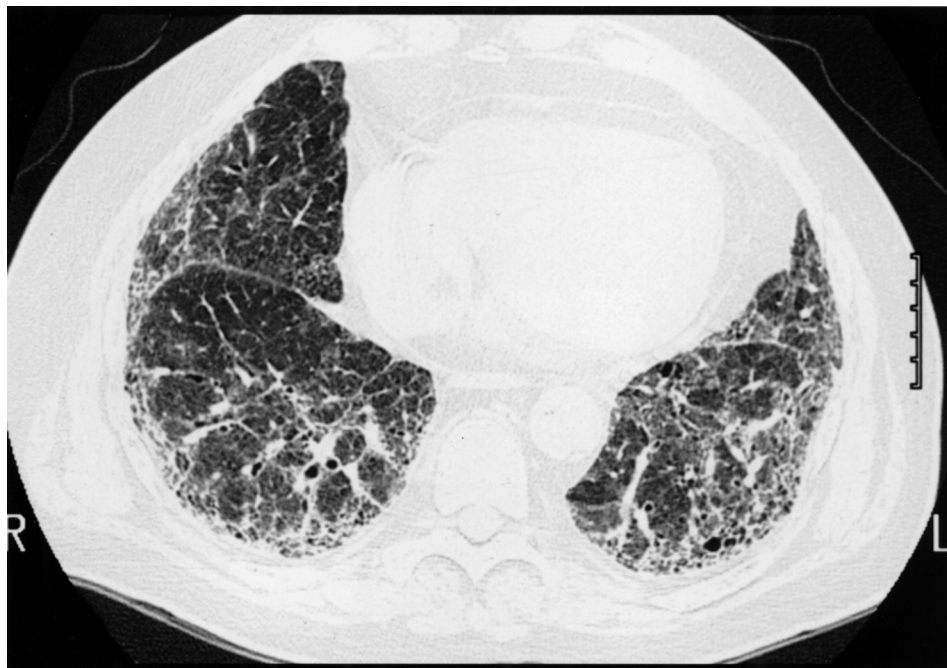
High resolution CT scan of the chest in a 67-year-old man with long-standing RA treated with multiple immunosuppressive medications. Bilateral, predominantly peripheral reticular and ground-glass infiltrates as well as honeycombing are visible. Open-lung biopsy result was consistent with usual interstitial pneumonia. He died at home 2 months later.
